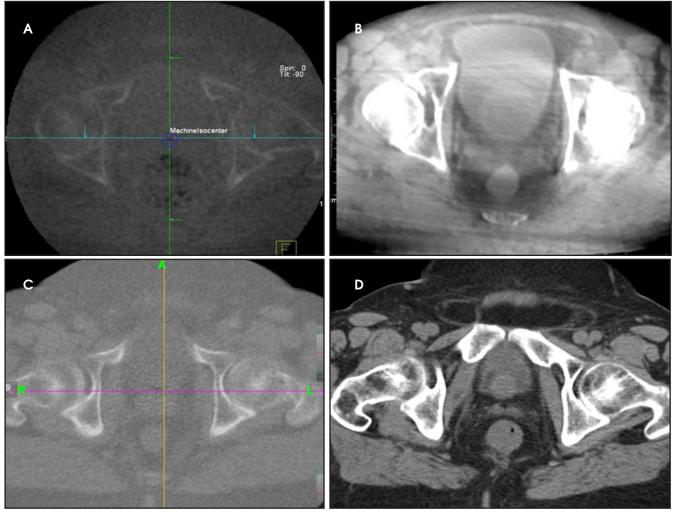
IGRT image quality comparison. Clockwise from top left, MV CBCT (A), kV CBCT (B), kV FBCT (C), and MV FBCT (D) axial slice of separate prostate patients. MV images courtesy of N. Morrow, Medical College of Wisconsin, Milwaukee, WI.
